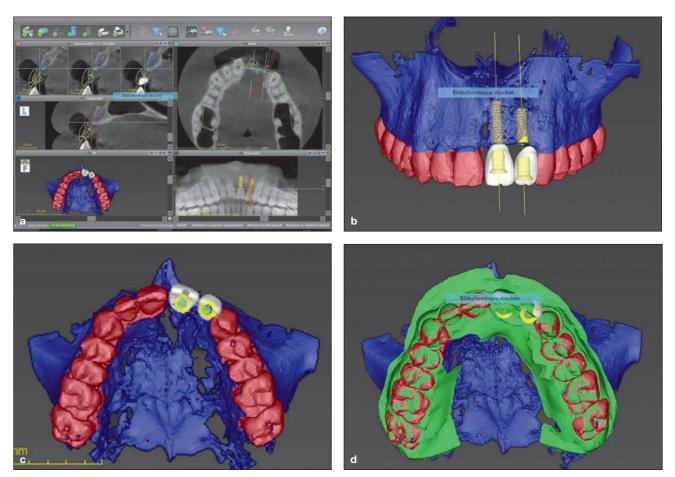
/ (a) Overview of the different planning software views. (b) Digital wax-up of the maxillary left incisors. (c) Occlusal view of the digital wax-up: palatal screw retention is planned. (d) Surface scanned data matched with the CBCT data.
